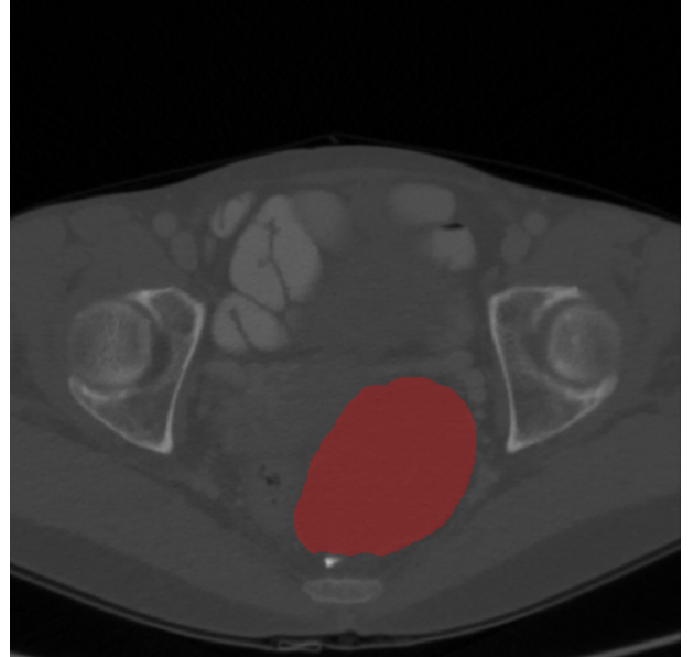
A 2D axial slice of the 3D-CT scan of a patient with ovarian cancer with the tumor marked in red.
